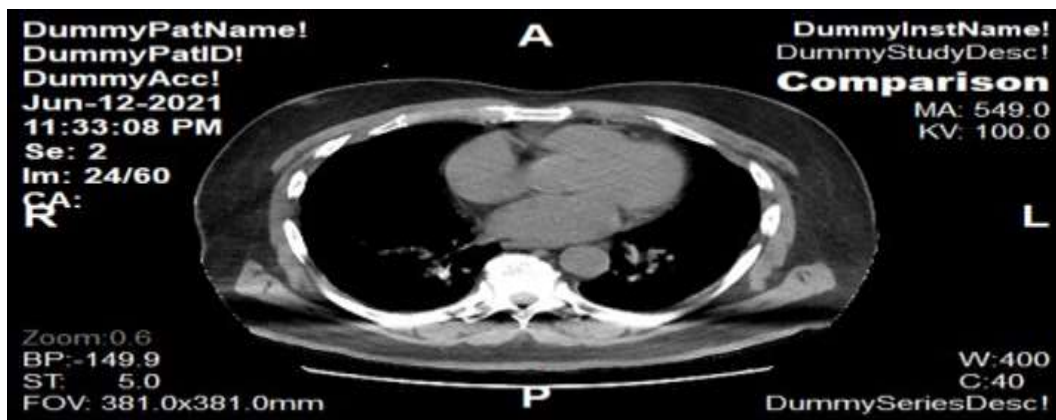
66 Years Old Male Complain of Severe Cough and Fever, his CT Image Follow-up Showed Improvement in his Bilateral Multiple Ground Glass Opacities.
